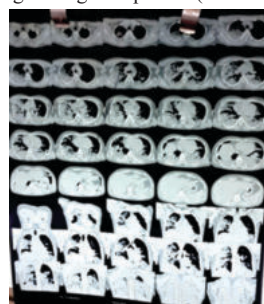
CT Chest on Day 3 shows patchy and peripheral consolidations with ground glass opacities.
